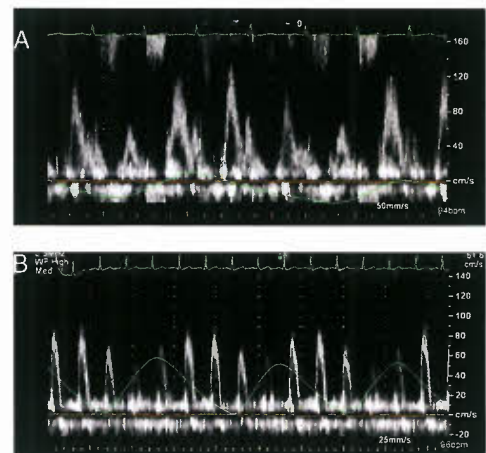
Doppler echocardiographic patterns seen in an adolescent patient with a large pericardial effusion and tamponade physiology, including (A) mitral inflow pulse-wave Doppler and (B) abdominal aorta pulse-wave Doppler signals. Note the marked respiratory variation (respirometer below Doppler tracing in each figure) in peak velocities of both LV filling and aortic antegrade flow.
